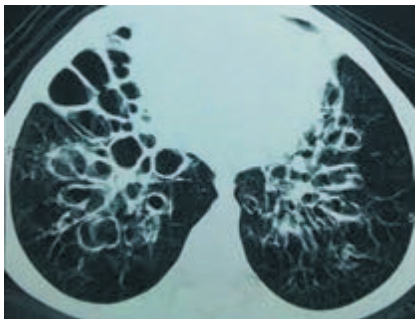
Cystic (left) and varicose (right) type bronchiectasis in HRCT
